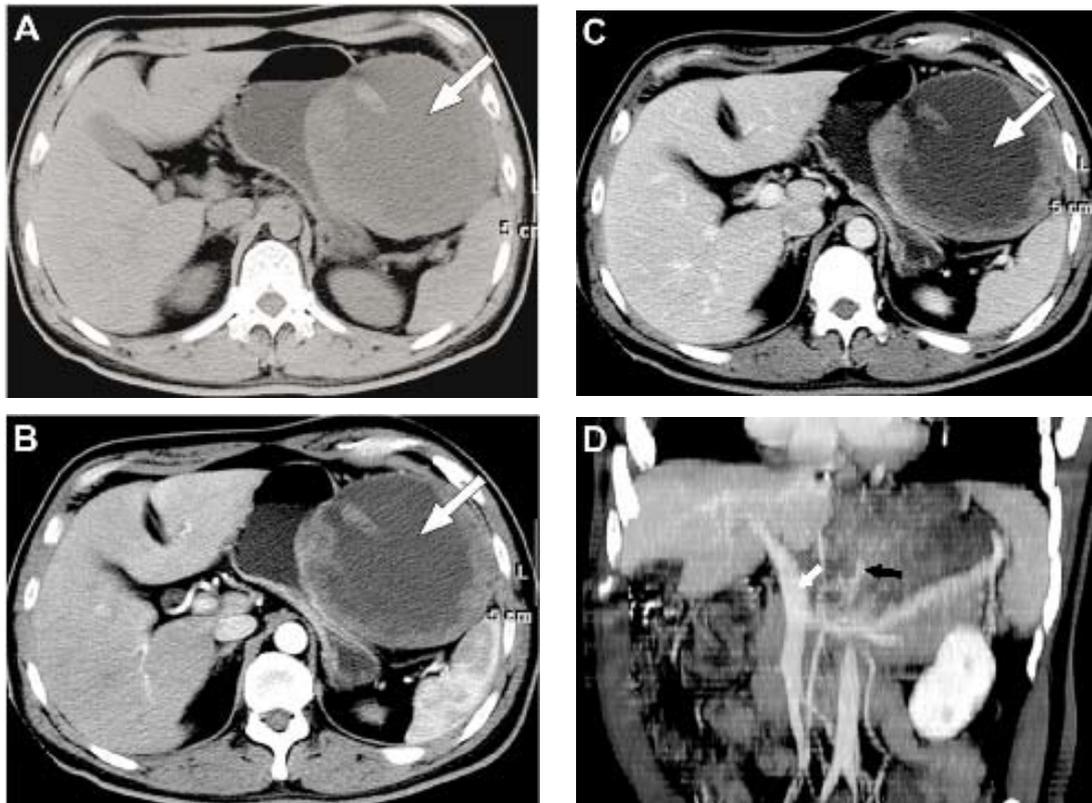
A 48-year-old man with a gastric gastrointestinal stromal tumors (GISTs) at high risk. a) Transverse plan scan showed an oval-shaped predominantly cystic mass (arrow) with a small air-fluid level (arrow head) located in duodenum. b) Contrast-enhanced CT scan showed the mass was circling enhanced (arrow), with a large necrosis area in the central area. c) Contrast-enhanced CT scan showed the entity of mass was further enhanced in venous phase. d) Multi planar reconstruction showed portal vein (black arrow) and celiac trunk (white arrow) are not invaded.
